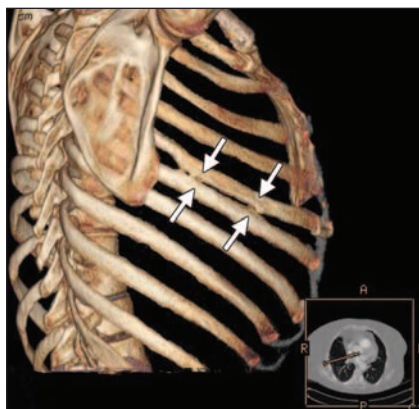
Three-dimensional reconstruction of helical chest computed tomography scan shows close contact between fifth and sixth ribs (arrows).
